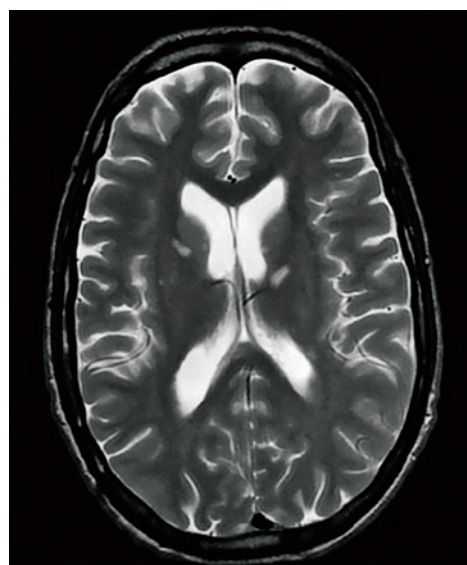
MRI of brain, axial view in T2 WI. Display of multiple periventricular areas of hyperintense signal at patient with CMV infection.
